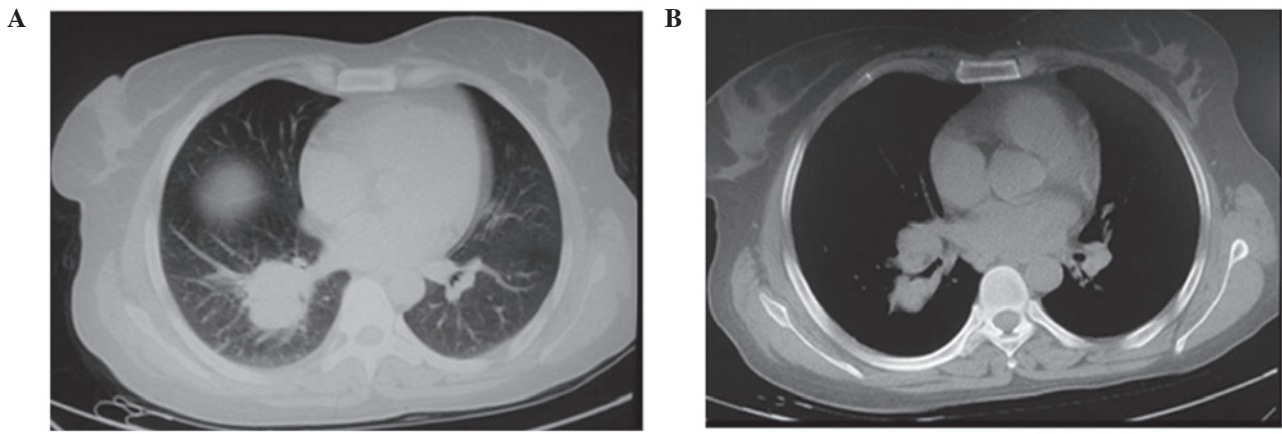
Conventional computed tomography scan of case 1, revealing a well-defined, homogenous mass at the lower lobes of right lungs, as well as enlarged nodes in the hilum and mediastinum. (A) Lung and (B) mediastinal window.
